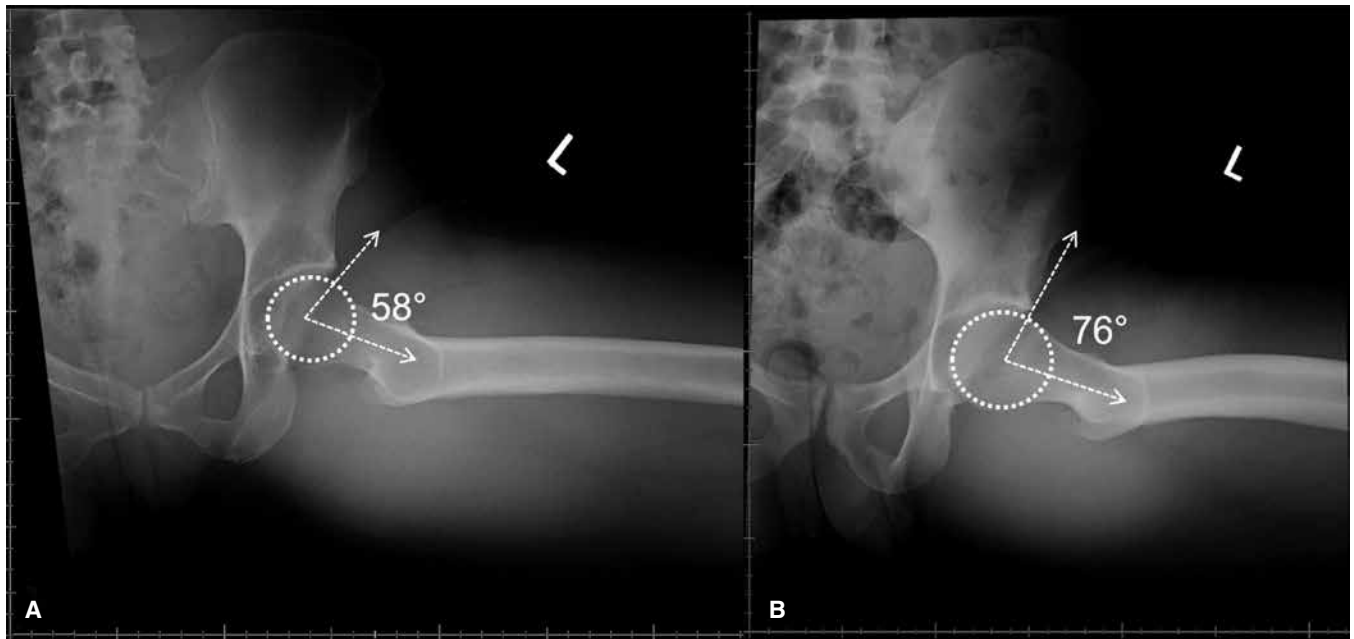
(A) Left Dunn lateral view radiographs of 31-year-old female with alpha angle measured at 58 degrees. (B) Left Dunn lateral view radiographs of 19-year-old male with alpha angle measured at 76 degrees, revealing asphericity of femoral head and neck and cam type morphology.
